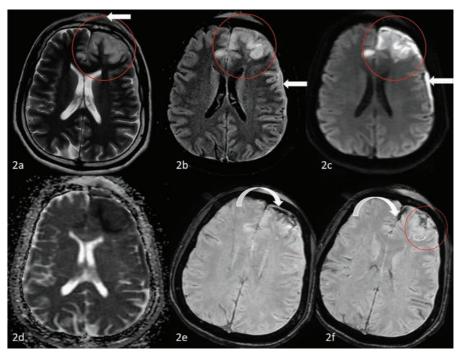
(a, b) Axial T2 weighted imaging (a) and FLAIR (b) showing hyperintensity involving the left frontal lobe (red circle) with inflamed soft tissue in the subgaleal region (white arrow). Note the subdural fluid collection along the left frontoparietal region (white arrow in 2b). (c, d) Axial diffusion-weighted images and apparent diffusion coefficient images showing diffusion restriction in the involved area, suggestive of acute infarction. Diffusion restriction is also noted in the subdural fluid collection, suggestive of empyema (arrow in c). (e, f) Susceptibility weighted imaging showing serpentine hypointense (susceptibility) structure running in the sulcal space adjacent to the infarct, indicative of thrombosed vein (curved arrows). Note the multiple punctate hemorrhagic foci within the infarcted area (red circle in f).
